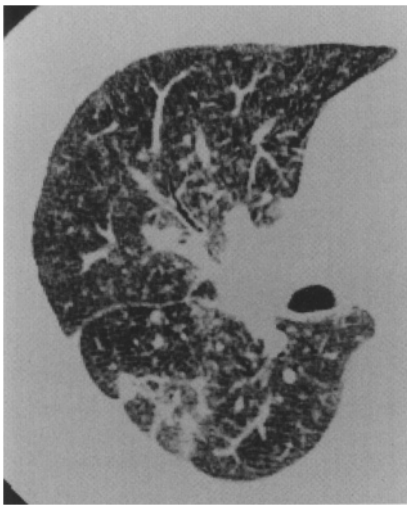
HRCT scan of talcosis. Diffusely distributed ill-defined small nodules and ground-glass opacity are seen
